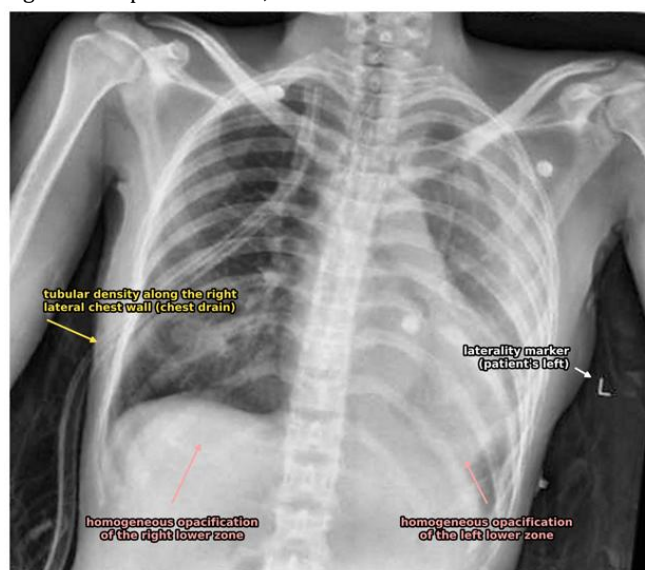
Anteroposterior chest radiograph obtained during the tertiary admission, with the right-sided chest drain in place. The image has been rotated to correct the tilt of the original capture, cropped to the radiographic field and contrast-normalised; no anatomical content has been altered and no patient identifier was present on the source image. There is homogeneous opacification of both lower zones with loss of the normal hemidiaphragmatic outlines and generally reduced lung volumes, the appearances reported at the time as persistent pleural effusion with reduced lung expansion. A tubular density runs along the right lateral chest wall in the expected position of the intercostal drain. The metallic marker on the patient's left confirms the orientation of the film.
